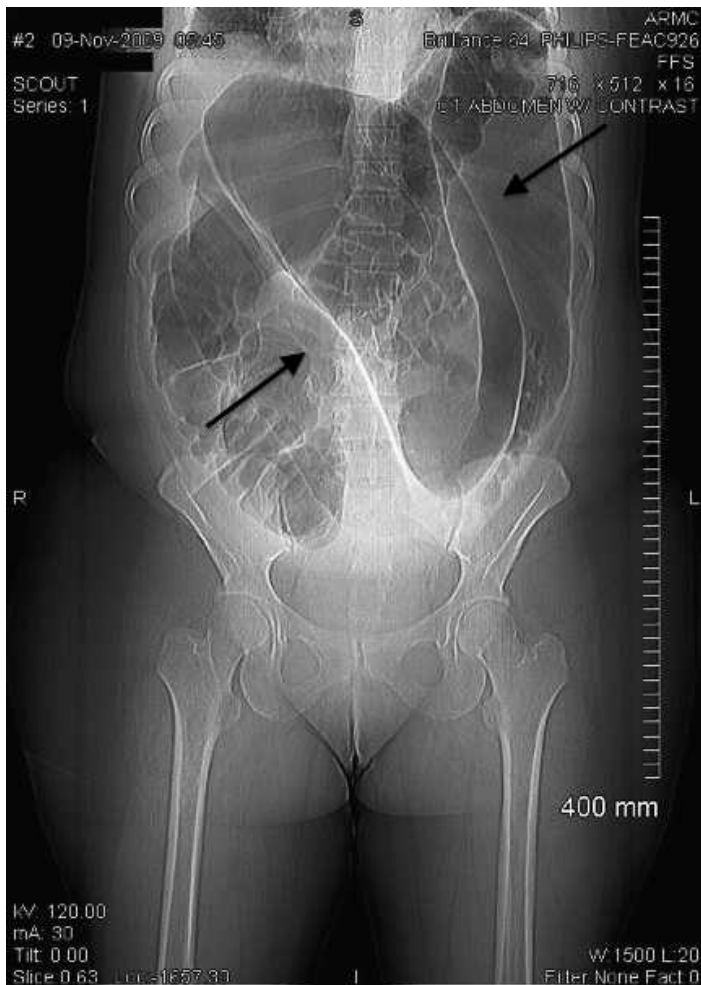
Computed tomography of abdomen showing “coffee bean sign.”
